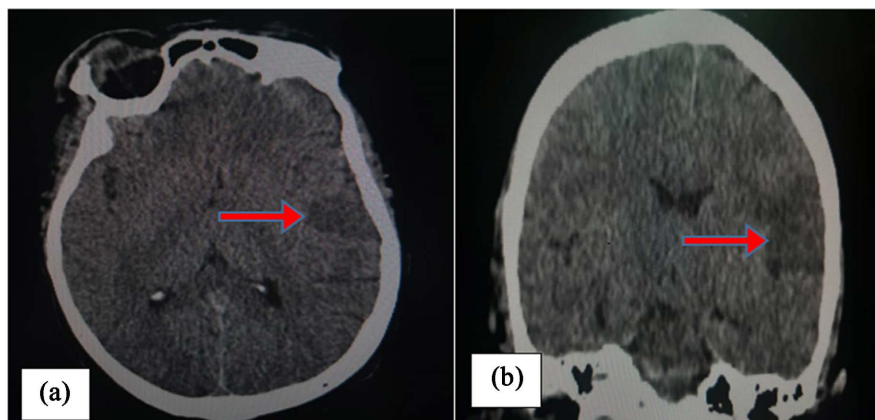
Cerebral computed tomography images without injection of contrast product during the patient’s hospitalization, in cross section (a) and frontal (b) highlighting the ischemic cerebrovascular accident in the form of a superficial hypo dense image of the left Sylvain valley (Red Arrow).
